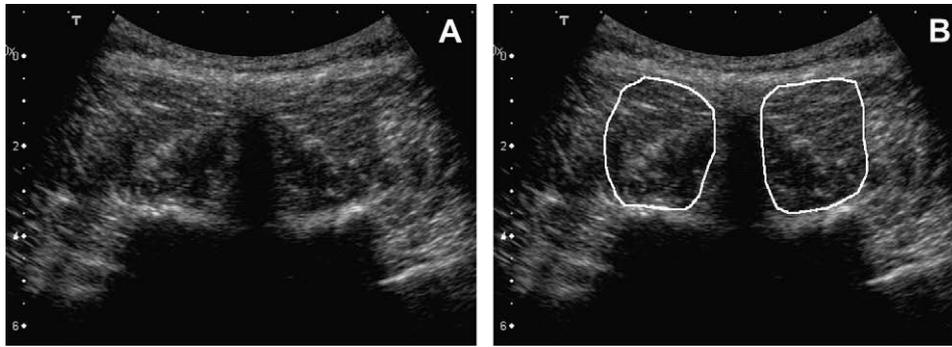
A. Bilateral transverse ultrasound image at the L4 vertebral level, without CSA tracings. B. Bilateral transverse ultrasound image at the L4 vertebral level with CSA tracings. The CSA (in cm^2) of the multifidus was measured by tracing around the muscle border with the on-screen cursor.
